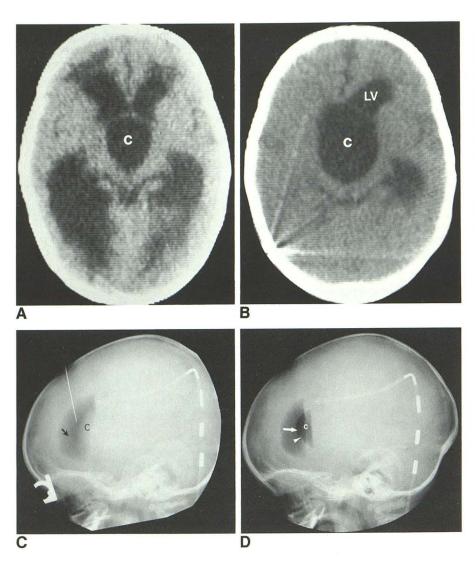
Case 8: 8-month-old boy with communicating SSAC producing intraventricular and extraventricular obstructive hydrocephalus. A, CT scan reveals large midline SSAC (C) causing obstructive hydrocephalus. B, After placement of right ventriculoperitoneal shunt. Complete decompression of right lateral ventricle. Obstruction of foramina of Monro by cyst prevents decompression of both left iateral ventricle (LV) and communicating SSAC by right ventricular catheter. C, Air introduced into left lateral ventricle (arrow) outlines dome of intraventricular component of cyst. Air initially fails to enter severely compressed third ventricle. D, Brow-up pneumoencephalogram demonstrates entry of air into communicating SSAC. A small amount of air has now passed through nearly occluded left foramen of Monro to enter severely compressed, slitlike anterior third ventricle (arrow). Anterior wall of cyst (arrowhead) is visible as a thin "web" between cyst and third ventricle. Air does not enter supratentorial cisterns because of a tentorial CSF block.
